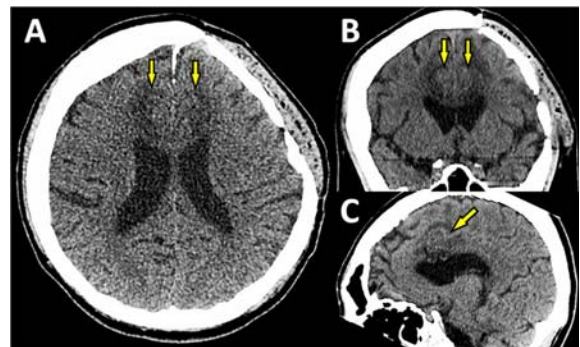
Cranial CT scan after bilateral anterior cingulotomy showing large bilateral stereotactic lesions of the anterior cingulate gyrus (arrow) in axial (A), coronal (B) and sagittal views (C).
